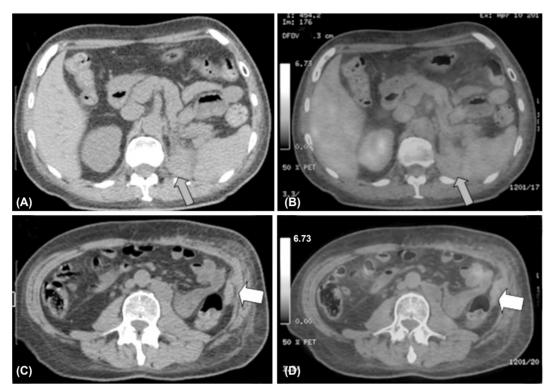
Axial CT and fused PET-CT images for a 57 year male patient with history of treated left renal cell carcinoma by left nephrectomy followed by chemotherapy.
